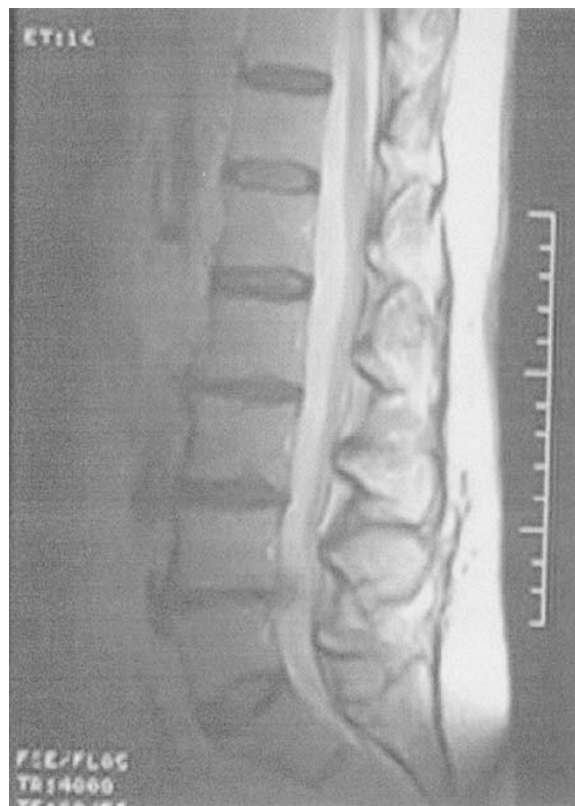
MRI (T2-weighted image) of the lumbar spine showing the disappearance of the pseudomeningocele
